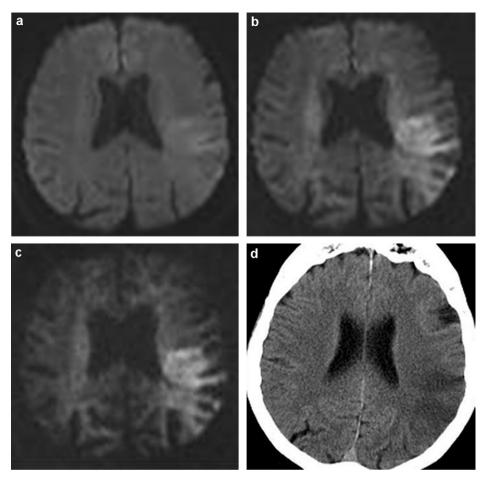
Occlusion of two branches of the left medial cerebral artery. Hyperacute infarction frontal and parietal. Delay from stroke onset was 195 minutes. Lesion conspicuity was higher, boundary was better seen and lesion extent was bigger on b = 5000 (c) and b = 3000 images (b) compared to b = 1000 images (a). Estimation of lesion extent compared to follow-up CT (d) 1 day later was best on b = 5000 images (c).
